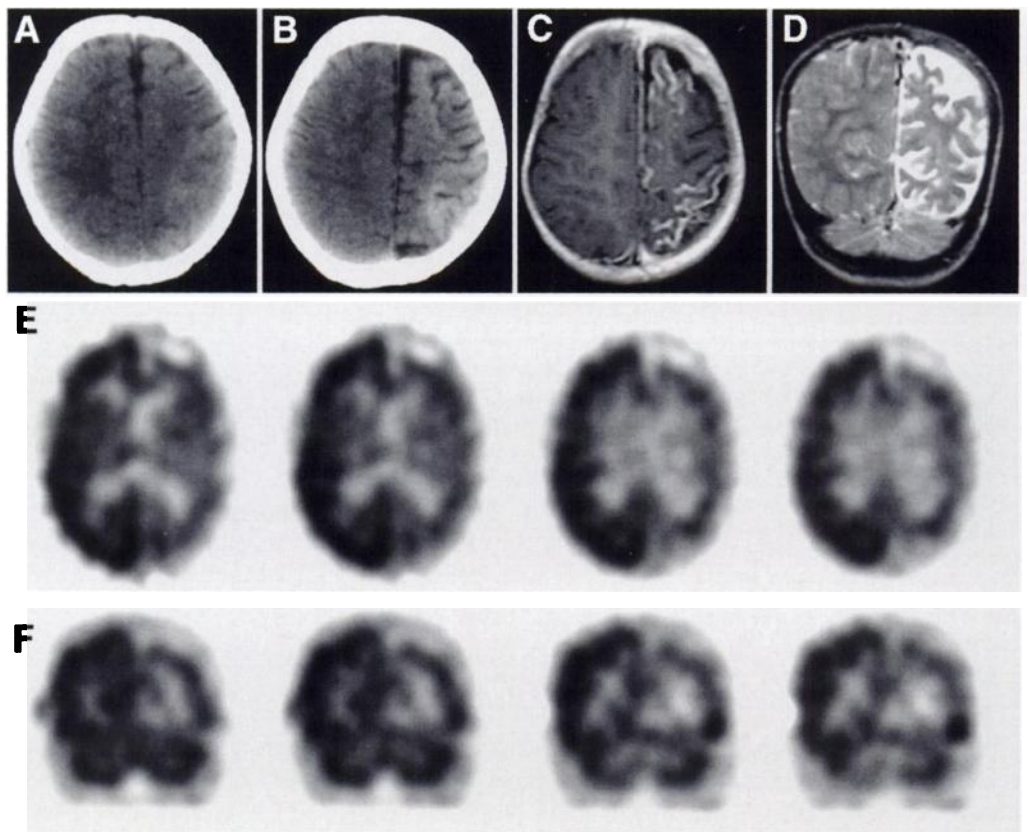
Nonenhanced CT (A) performed at age 5 mo reveals minimal prominence of the left frontal sulci and subtle high density of the parietal gyri. Nonenhanced CT (B) at age 22 mo demonstrates progressive sulcal widening and high-density calcifications. Gadolinium-enhanced, T1-weighted axial (C) and T2-weighted coronal MRI (D) show left frontal and parietal cortical enhancement and cortical atrophy. Transverse (E) and coronal (F) ^{99m}Tc -HMPAO SPECT reveal markedly diminished tracer localization in the left cerebral hemisphere.
